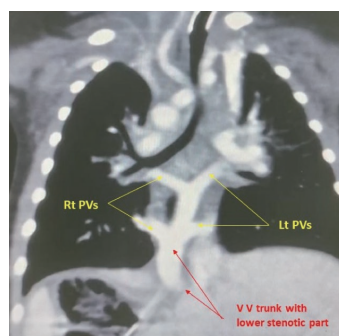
Computed tomography angiography revealing infracardiac type total anomalous pulmonary venous connection (TAPVC) with a vertical vein going downward (with a lower stenotic segment), and four pulmonary veins joining it separately. Lt PVs, left pulmonary veins; Rt PVs, right pulmonary veins; VV, vertical vein.
